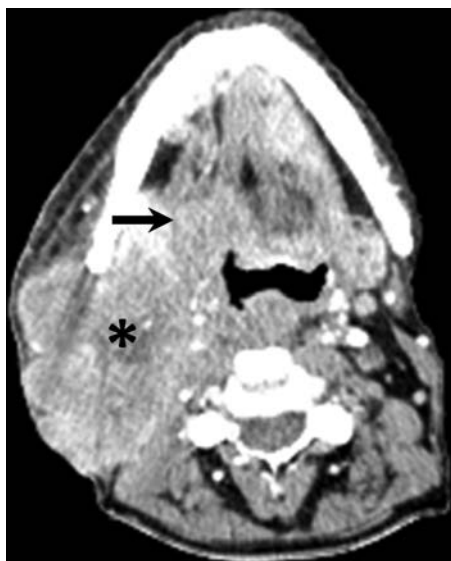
An example of radiographic extracapsular spread associated with a solid metastatic level II nodal mass (black asterisk) in a patient with right base of tongue oropharyngeal squamous cell carcinoma (black arrow).
